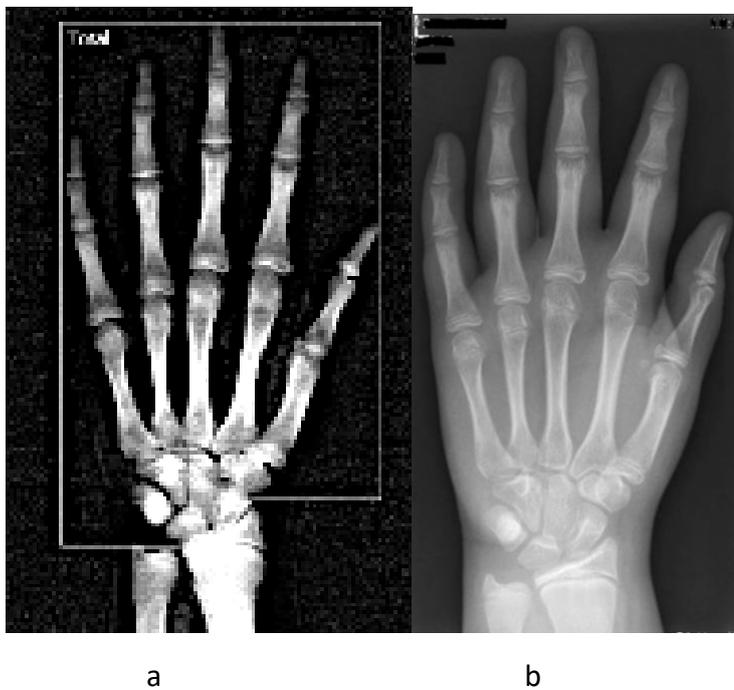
Example of good quality DXA image with corresponding radiograph (female; 12 years 11 months). (a) left hand DXA, (b) left hand radiograph
